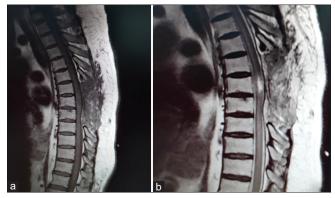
(a) T1WI. (b)T2WI Postoperative MRI showing gross total resection of IMSCm
